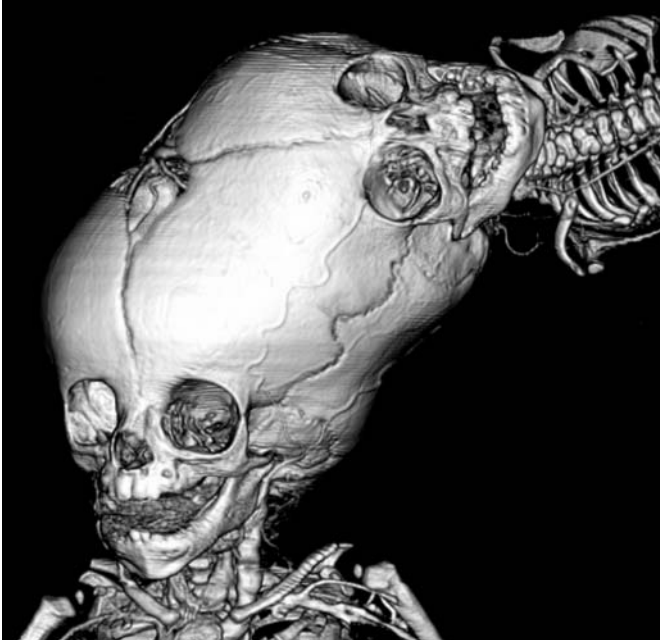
CT scan of the cranium with 3-D reconstruction. The left frontal, parietal, and temporal bones of the autosite join the right frontal, parietal, and temporal bones of the parasite.
